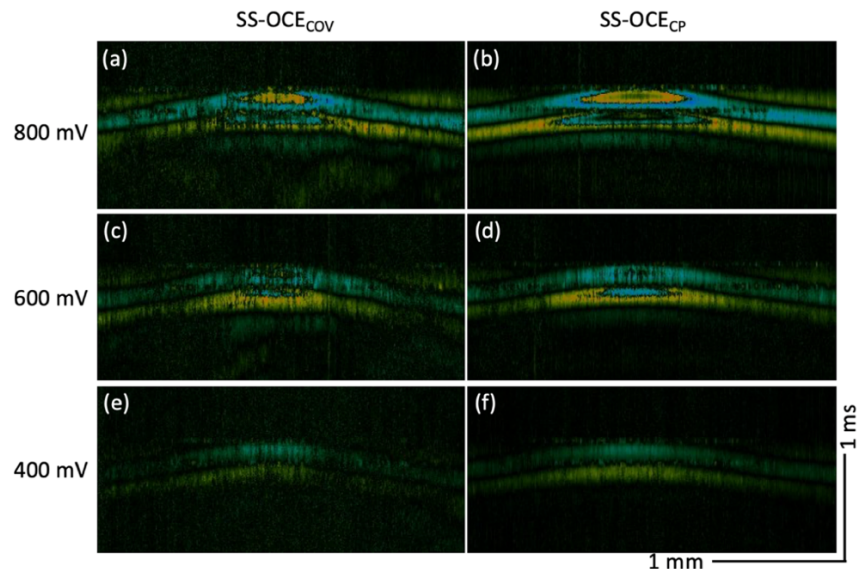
Spatiotemporal Doppler OCT of the cornea with different ARF. (a), (c), and (e) B-scans from SS-OCE<sub>COV</sub> excited with large, medium, and small ARF, respectively. (b), (d), and (f) B-scans from SS-OCE<sub>CP</sub> excited with large, medium, and small ARF, respectively.
